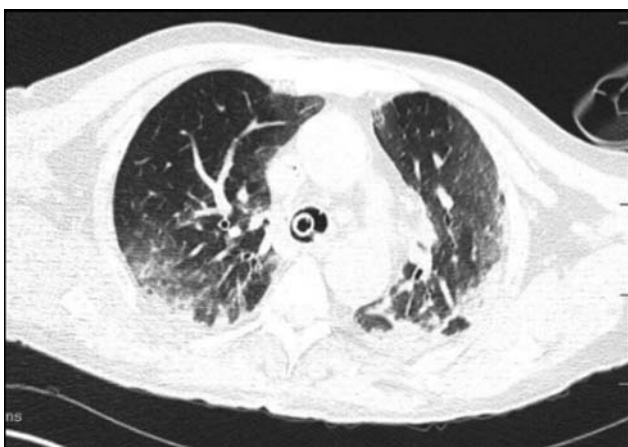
Postoperative axial chest computed tomography scan exhibiting multilobed ground-glass opacities, suggestive of SARS-CoV2 infection.
